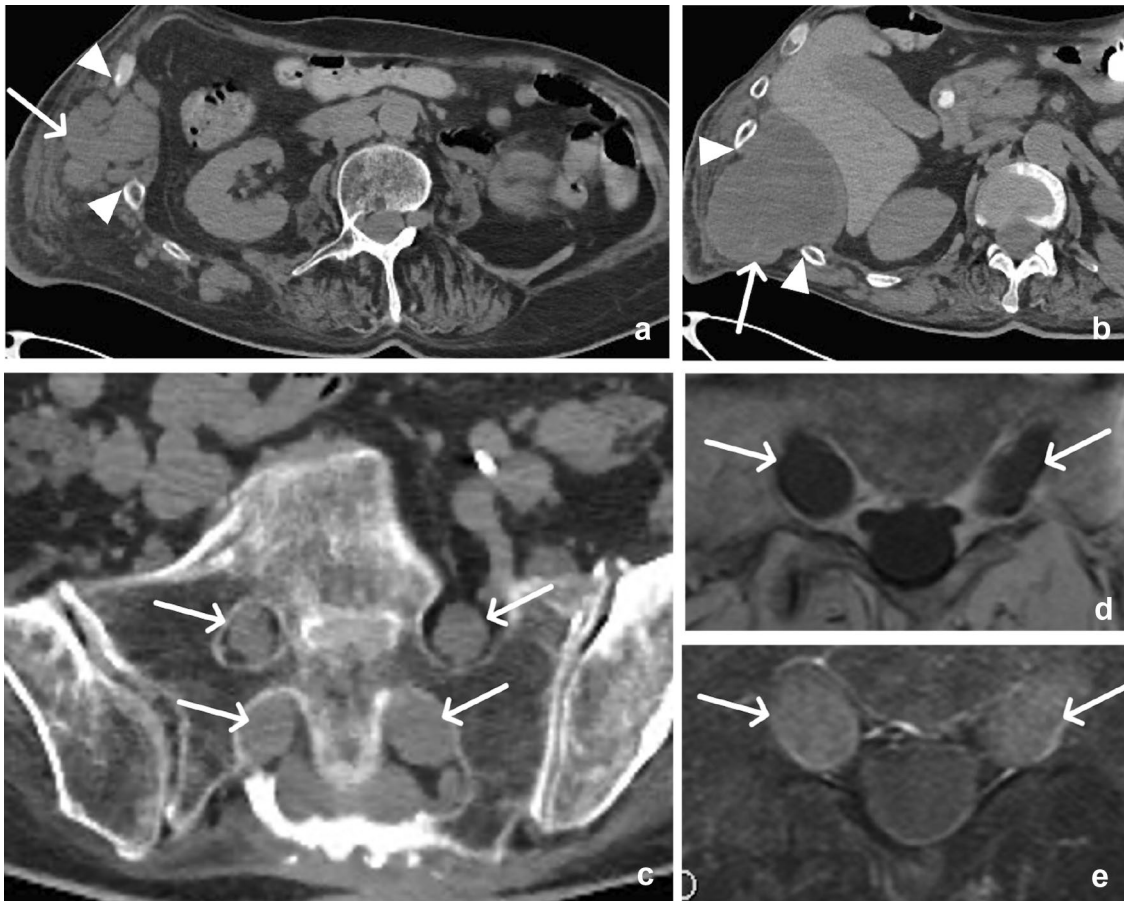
46-year-old male with Neurofibromatosis type I demonstrating chest wall and sacral neurofibromas. Axial CT images (a, b) demonstrate soft tissue masses (arrow) in the posterolateral chest wall with widening of the intercostal spaces (arrowheads) and smooth remodeling of the adjacent costal margins. Axial CT through the sacrum (c)
